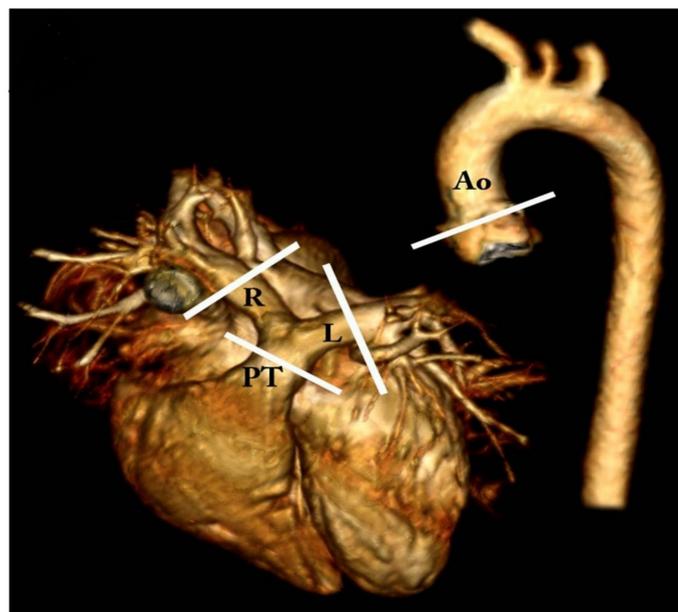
Location of analysis planes in the aorta and pulmonary system used for flow quantification based on 2D CINE PC and 4D flow MRI. Ao: Aorta, PT: Pulmonary trunk, R/L: right/left pulmonary artery.
